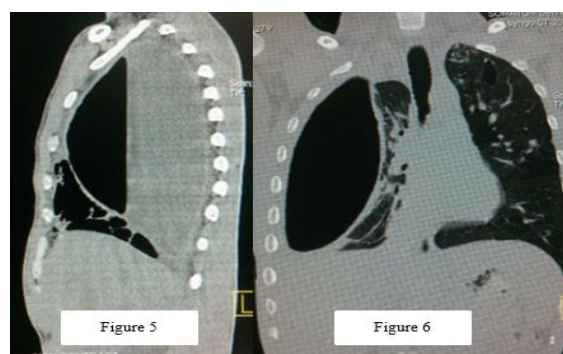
CT scan of the thorax sagittal and coronal sections
